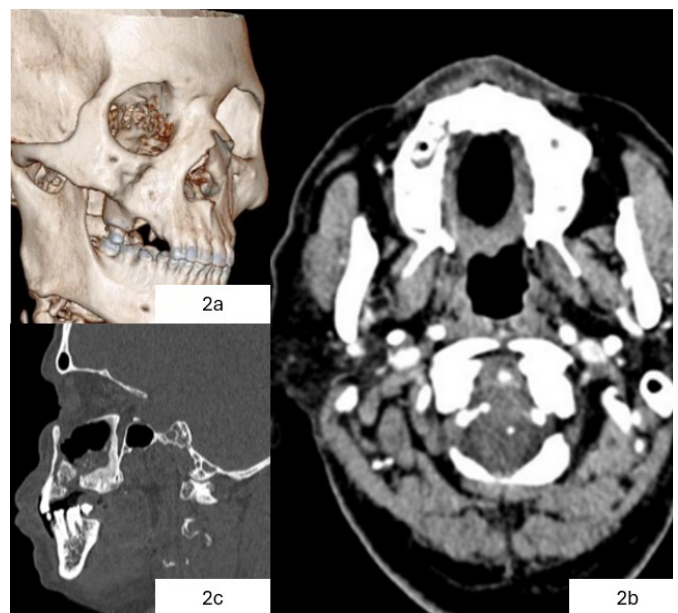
Contrast-enhanced computed tomography images. (a) 3D reconstructed image. (b) Axial section. (c) Sagittal section
